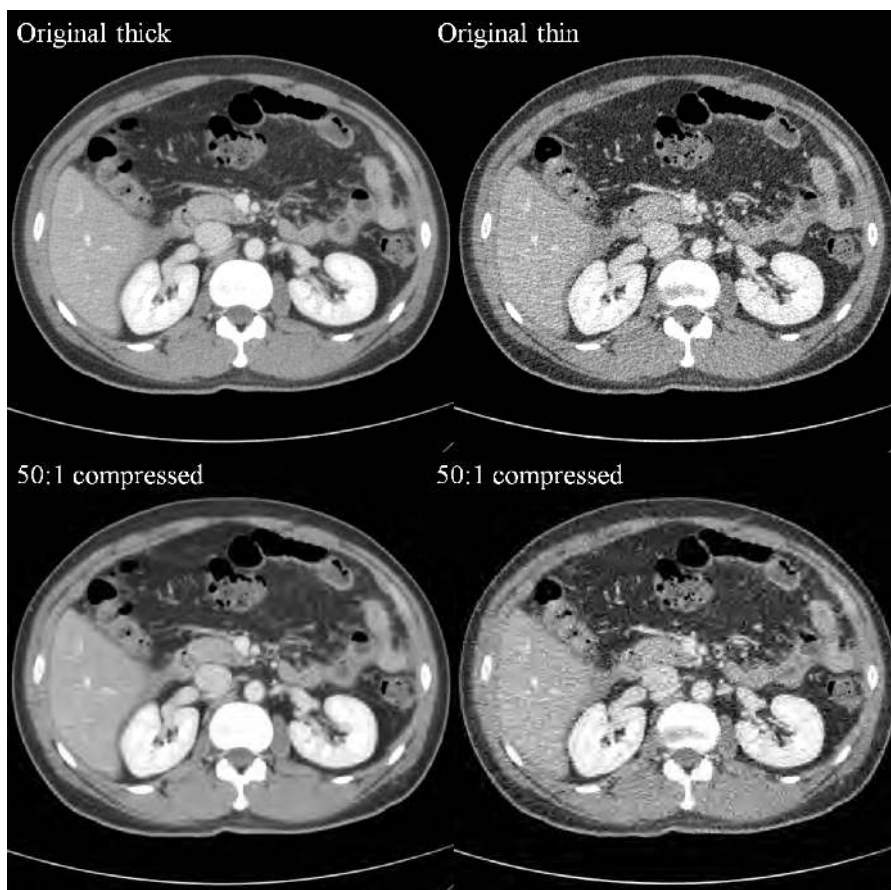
Example of the CT images used in calibrating the HDR-VDP. Top left image is a thick-section image and top right image is the thin-section image at the same z-position. Thin-section image is much noisy. To better present compression artifacts, we used compression ratio of 50:1 for these images, which was not tested in our experiment.
